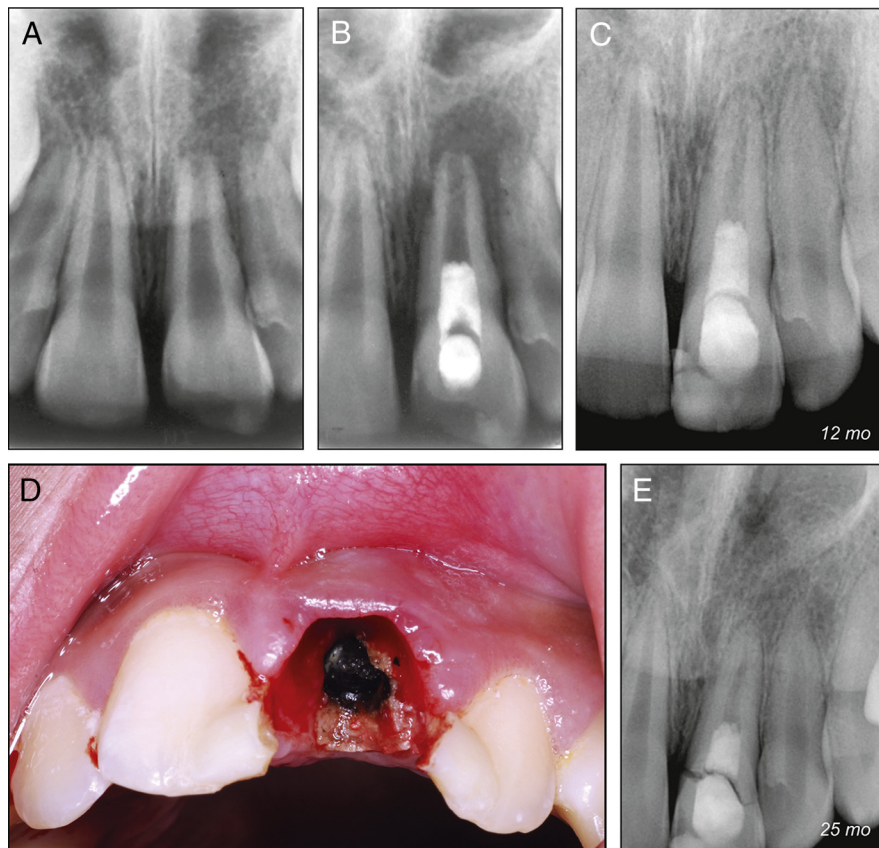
(A) Preoperative radiograph: tooth #9 exhibits incomplete formation of the root. Periapical radiolucency is present. (B) Postoperative radiograph: the periapical radiolucency appears to be larger than the preoperative lesion, with sharp margins. (C) Follow-up radiograph taken 12 months after revitalization: the periapical radiolucency has resolved with only slight thickening of the periodontal ligament around the root apex. The canal space is reduced in size and the thickness of the canal walls is increased. (D) The patient presented after 25 months because the crown was mobile. A complete crown fracture was diagnosed, and the tooth could not be restored. Clinical view after removal of the fractured crown. (E) Radiograph taken before removal of the fractured crown. Thickening of the root canal walls increased further. The periapical lesion completely resolved.
